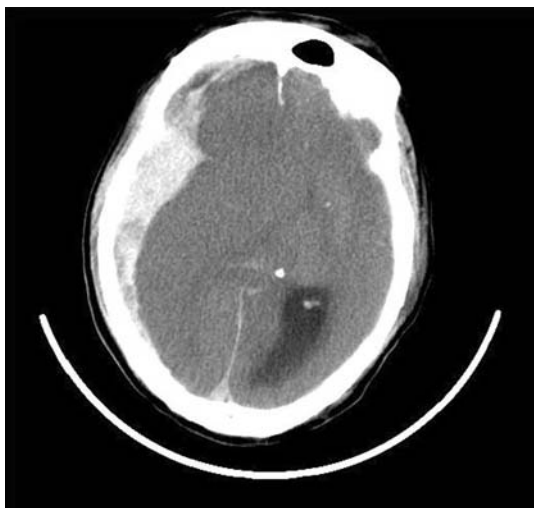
Case 15. This CT image shows a subdural hematoma on the right side. A midline shift and lateral ventricular dilatation can be seen
